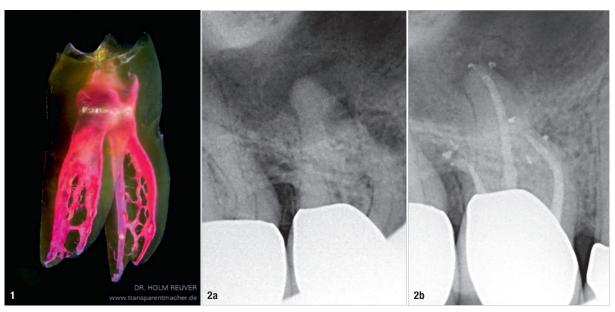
Mandibular molar canal system. (Image: © Dr Holm Reuver) Figs. 2a & b: Maxillary molar. Diagnostic radiograph (a). Post-operative radiograph (b). (Images: © Dr Holm Reuver)
